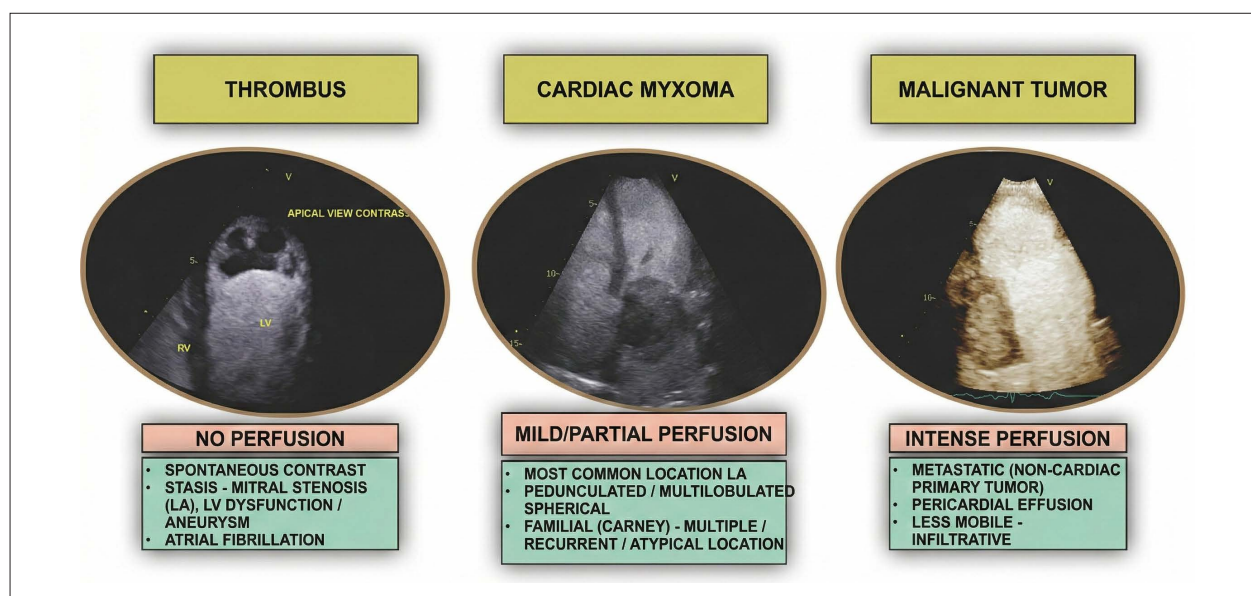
Examples of the use of an ultrasound-enhancing agent for the evaluation of mass perfusion.
